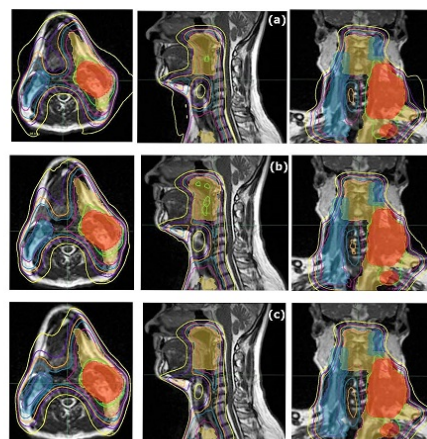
MRI-guided deformable dose accumulation displayed in axial, sagittal and coronal slices for (a) No Adaptation (b) adaptation after 22 fraction and (c) weekly adaptation for one of the head and neck cases included in this study. Note that 70Gy: Green, 60Gy: Pink, and 54Gy: blue. PTV70: Red, PTV60: yellow, and PTV54: blue.
